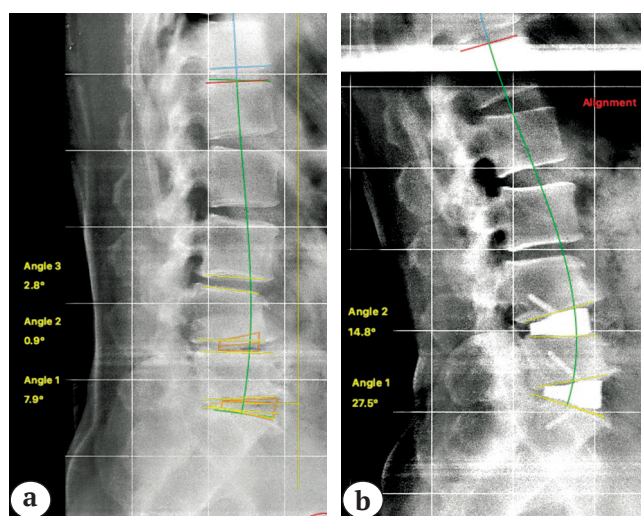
Measurement of segmental and lumbar lordosis using the Surgimap program: a – X-ray of the patient before the operation (on the left are the values of the angles L5–S1 = 7.9° , L4–L5 = 0.9°); b – X-ray of the same patient after individual interbody cage implantation (values of the obtained angles of segmental lordosis L5–S1 = 27.6° , L4–L5 = 14.8°)
